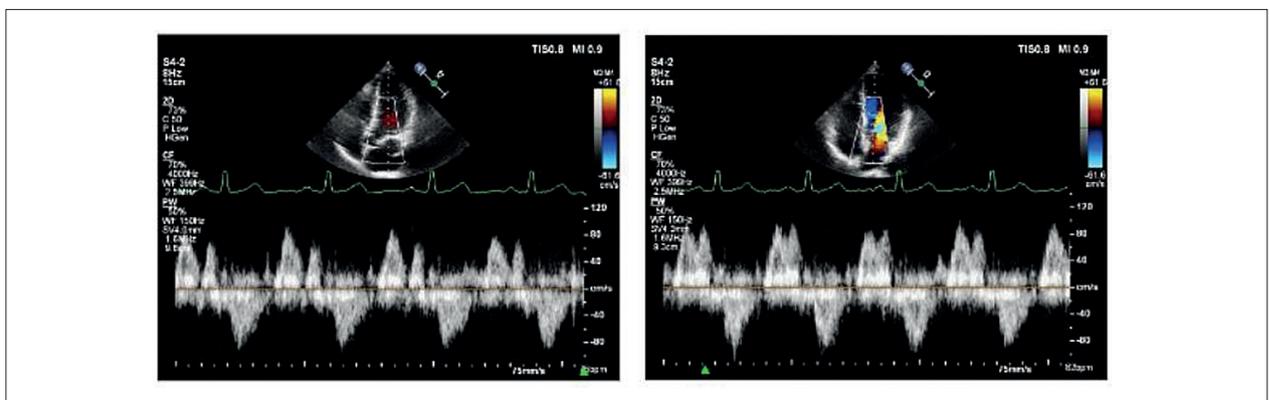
Echocardiographic images in the Apical 4-chamber view of the inflow tract and outflow tract of the left ventricle with pulsed Doppler.
